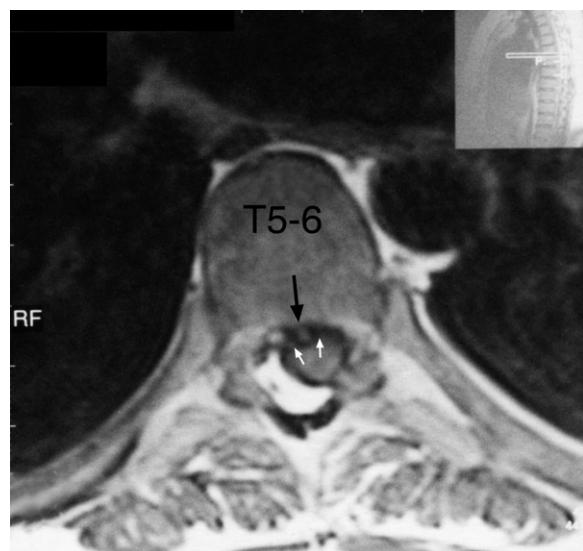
Thoracic spine MRI axial T1-weighted image at the T5–6 level. Note the protrusion (arrow) that is essentially central and impinges upon the dural tube anteriorly (small white arrows).
